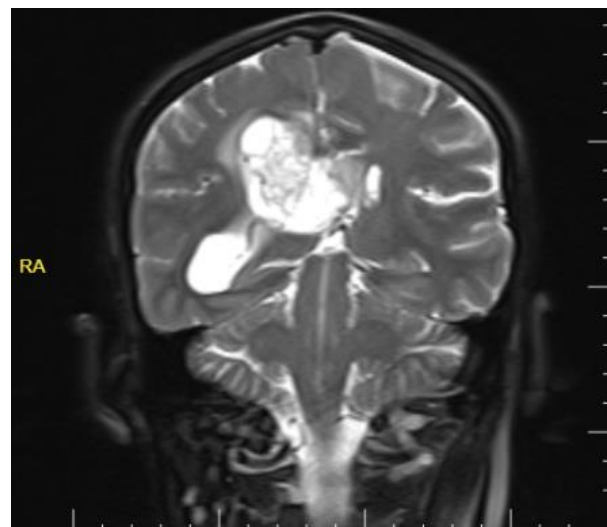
Brain MRI T2 Coronal View showing hyperintense intraventricular mass lesion with mild edema around it and lateral ventricular compression.
